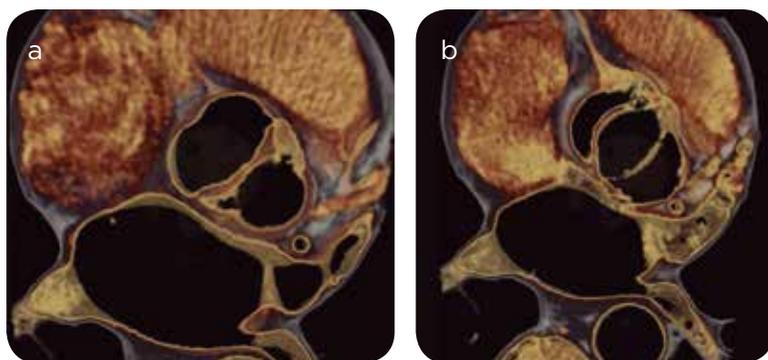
Cardiac CT in a patient with bivalve aorta without stenosis. 3D reconstruction in systole a) and diastole b).
